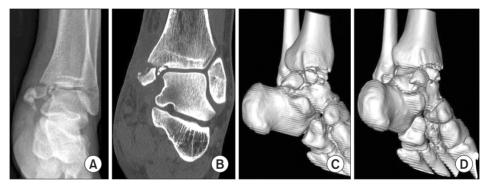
(A) Radiographic image of an ankle of a 23-year-old woman showing an isolated medial malleolar fracture with a comminuted anterior collicular fragment. (B) Coronal computed tomography (CT) image. (C, D) Three-dimensional reconstruction CT image of the medial malleolus. Multiple displaced fragments of the medial malleolus were too small to be fixed with a 4.0-mm cannulated screw or tension band wiring.
